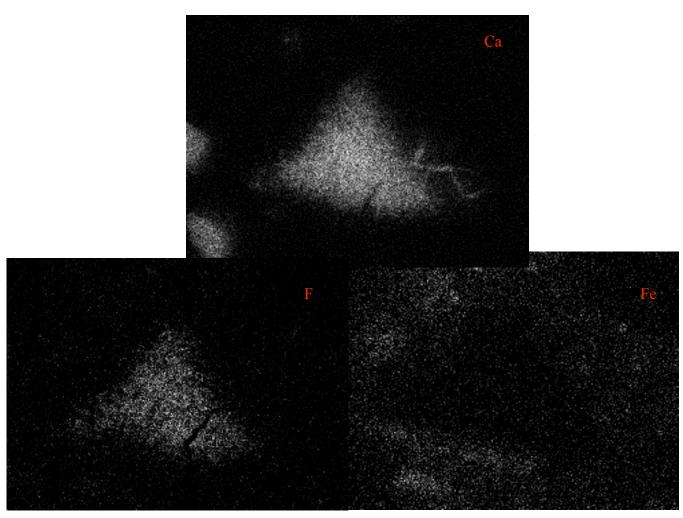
X-ray maps of fluorite TIND 1-3.
